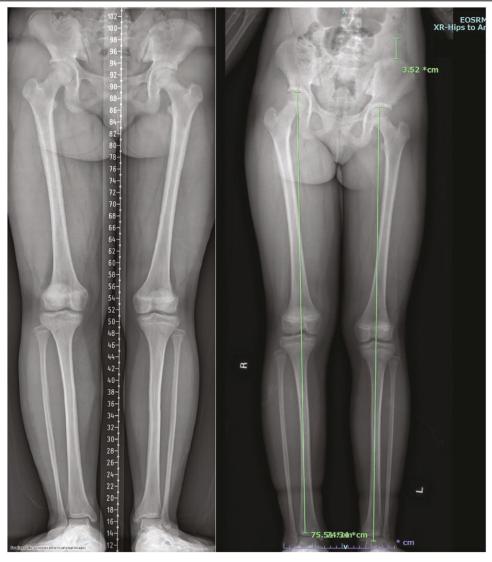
Anteroposterior bilateral lower extremity X-rays. Left panel: with a measurement ruler for scale. Right panel: without ruler, detecting a leg length discrepancy of 3.52 cm between the legs, with lengths of 75.54 cm and 84.8 cm, respectively.
